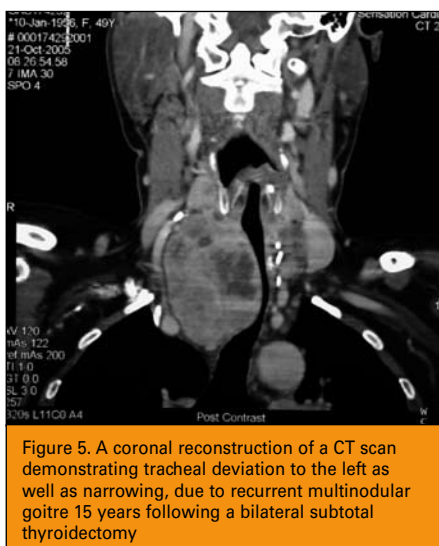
A coronal reconstruction of a CT scan demonstrating tracheal deviation to the left as well as narrowing, due to recurrent multinodular goitre 15 years following a bilateral subtotal thyroidectomy
